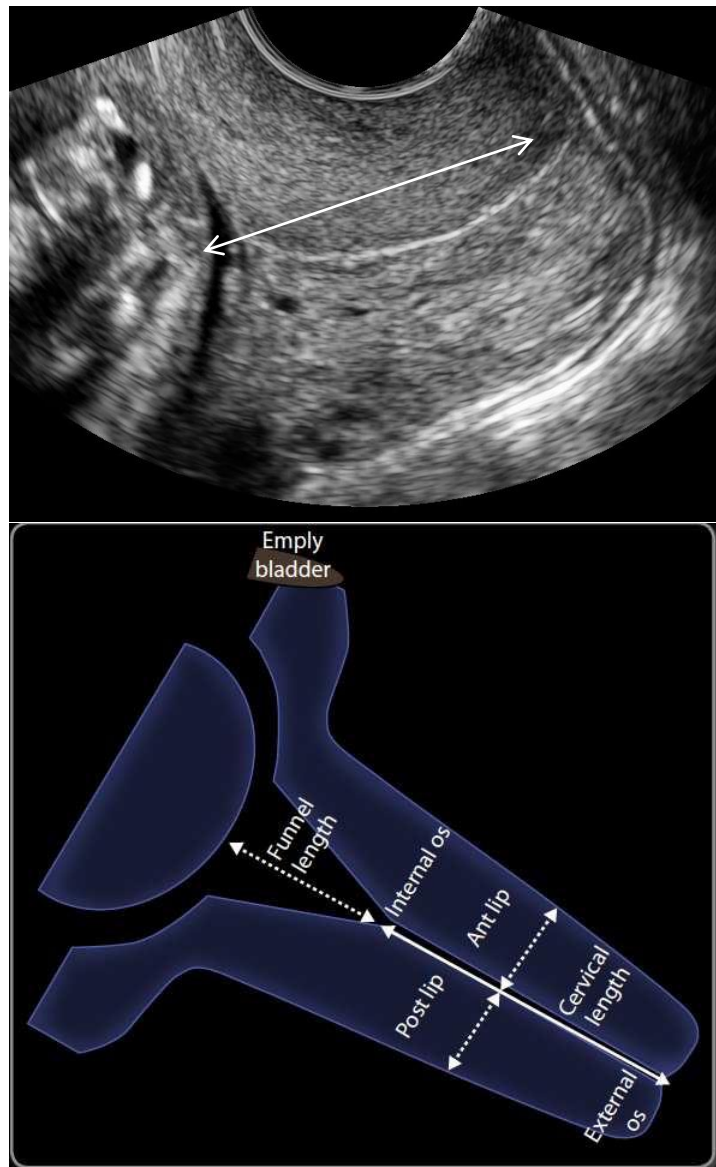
How to Measure Cervical Length on Transvaginal Ultrasound
